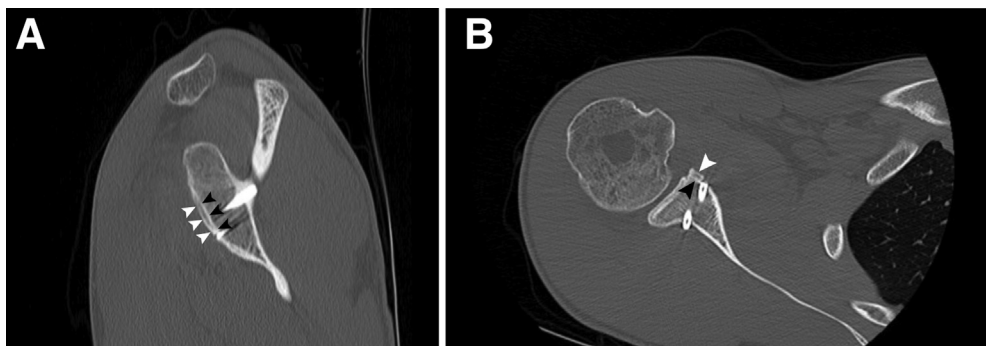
Sagittal and axial computed tomography images showing nonunion (A) and near-complete resorption (B) of the distal tibial allograft in the right shoulder of the patient (white arrow, new cortical bone; black arrow, original cortical bone).
